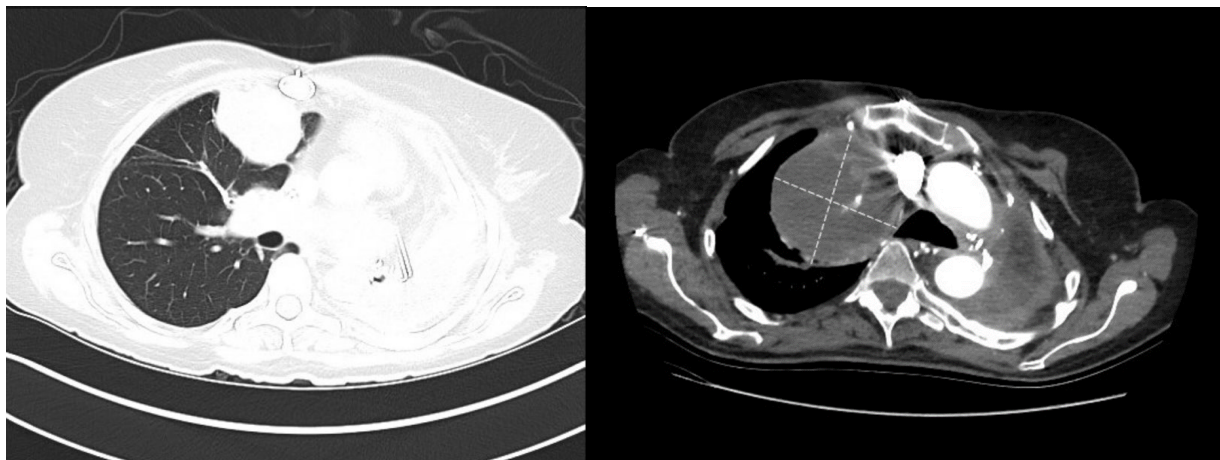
Images of chest CT demonstrating the right apical lung mass abutting the trachea.
